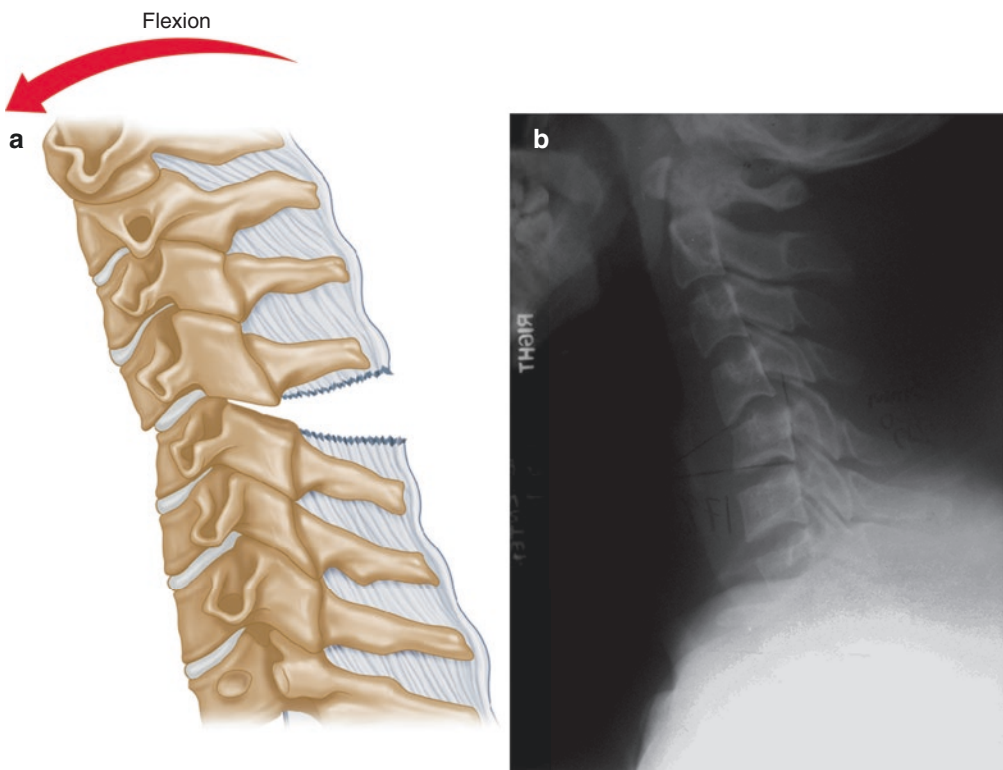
(a) Flexion injury leads to compression injury of anterior elements and tension injury of posterior elements. (b) Lateral X-ray of flexion injury of C-spine
